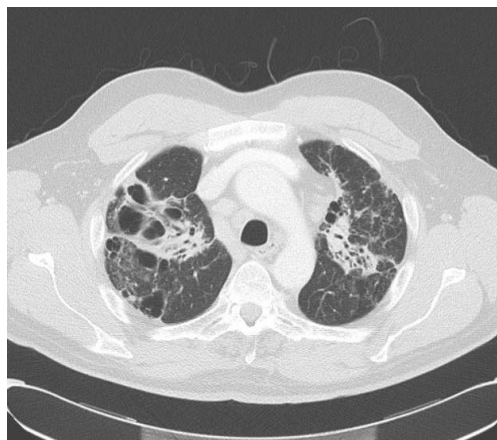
CT Chest with Bilateral upper lobe fibrosis
